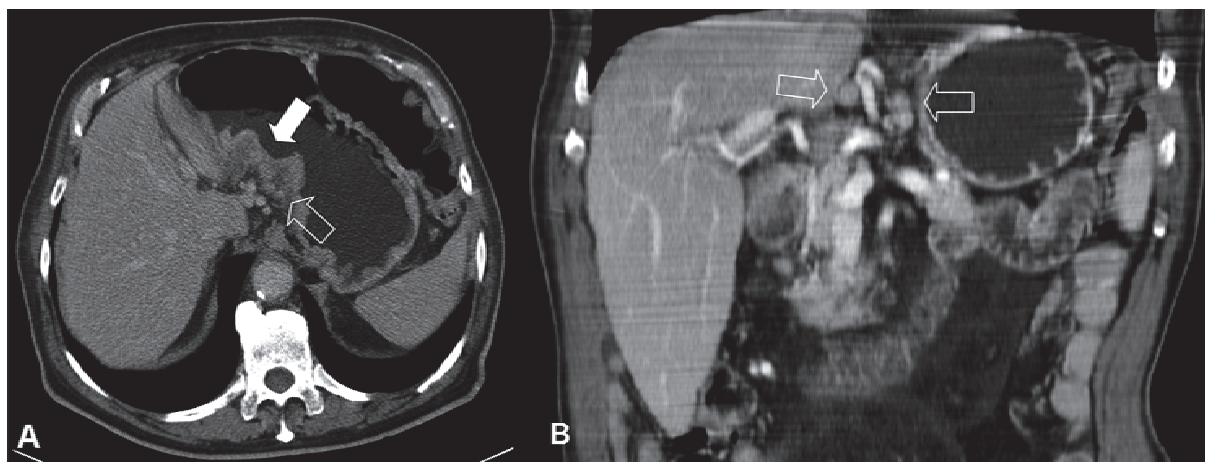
A. CT Transverse Scan. B. CT Coronal Reconstruction. The tumoral tissue is well evident (arrow). Several suspected peri-gastric lymph nodes are associated (empty arrows).
